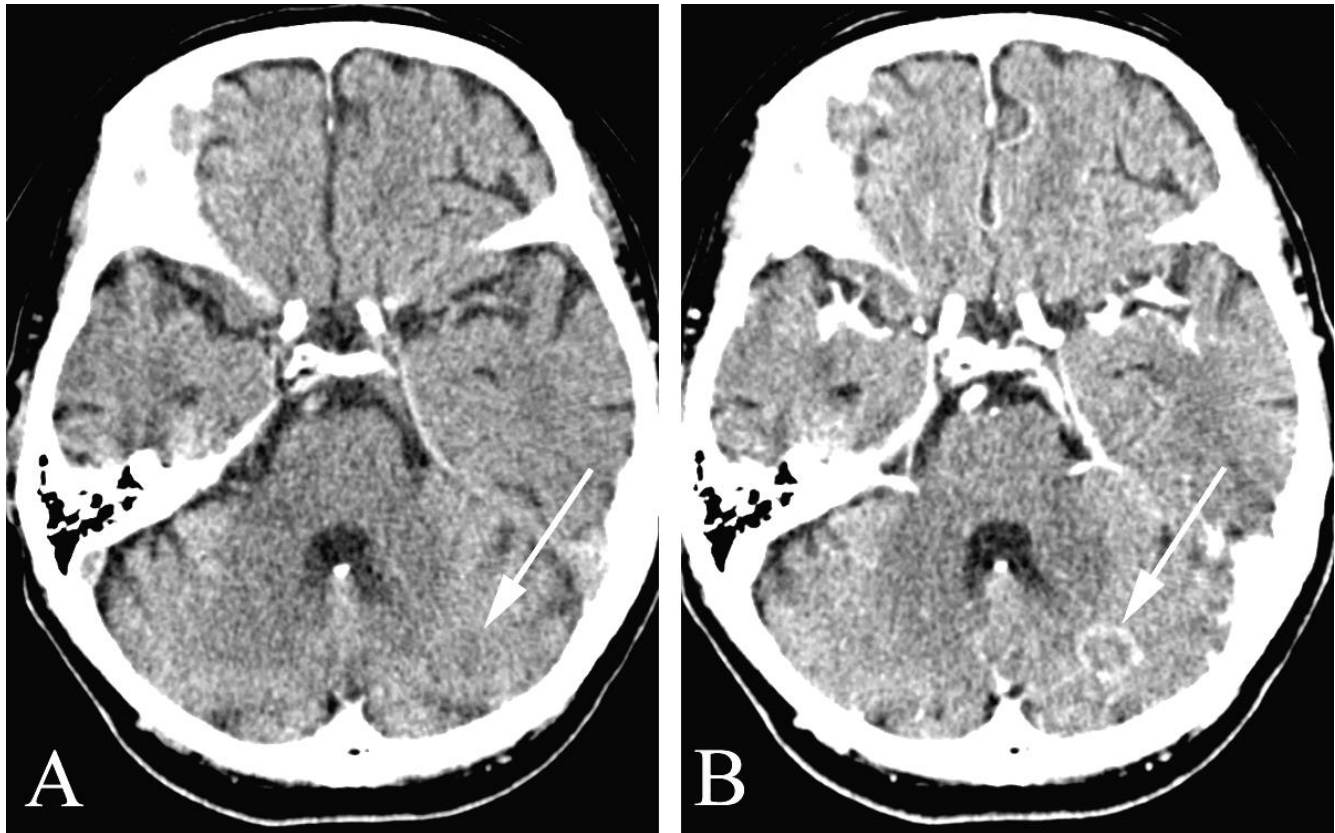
Metastatic disease in a 74 year old man with headache who had known lung cancer. A. Axial unenhanced CT study shows a subtle area of hypodensity in the left cerebellar fossa (arrow). B. Axial contrast enhanced CT shows a “rim enhancing lesion” (also called a “ring enhancing lesion”) with peripheral contrast enhancement around a centrally isodense lesion compatible with metastatic disease (arrow). Note that such rim enhancing lesions may also be seen in primary brain tumors and abscesses.
